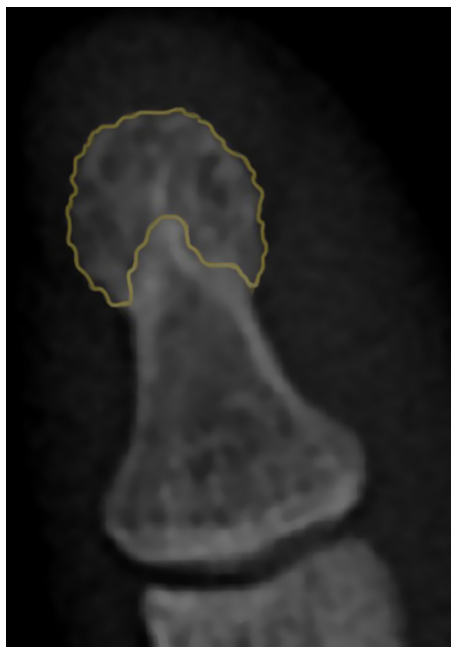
Radiographic image of the normal tuft. The orange-colored region delineates the area corresponding to the PTF. It indicates the typical tapering aspect of the cortical bone. The coloring appears only in the online version of the journal.
